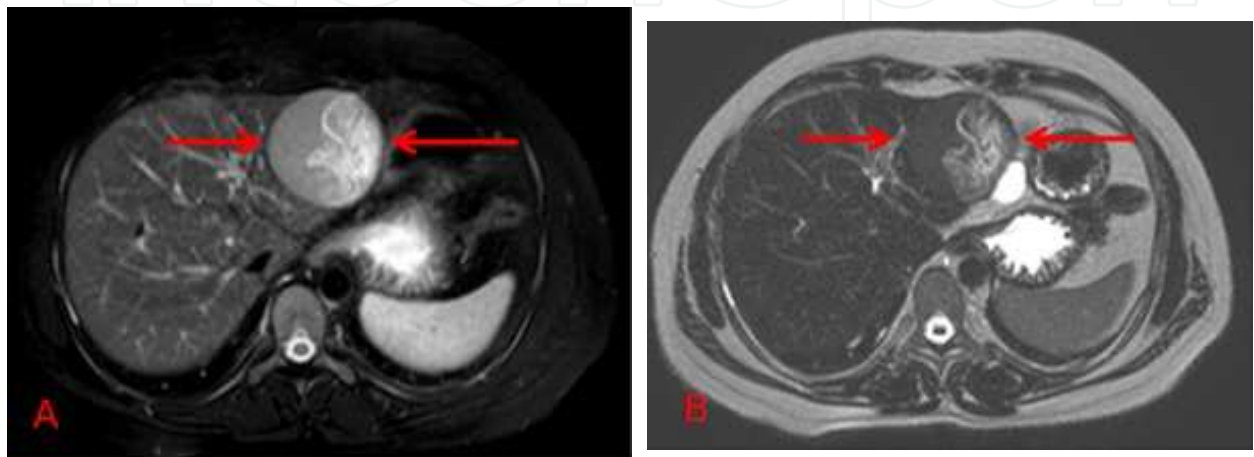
A,B: MRI T2W (A) and Heavy T2W (B) images show hypointense cyst hydatid lesion with a hyperintense split wall located at the left liver lobe (Gharbi Type 2, WHO C3a).
